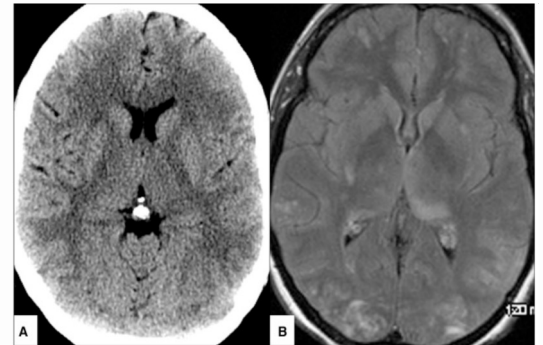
(a) CT and (b) MRI brain with disease process of parieto-occipital brain.<sup>1</sup>
